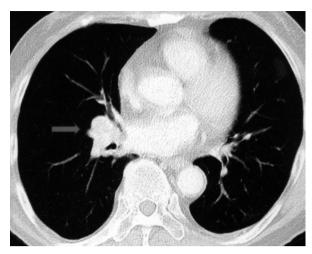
Chest CT revealed the soft tissue mass at the right lower lung had decreased in size after TK inhibitor treatment for 3 months (arrow)
